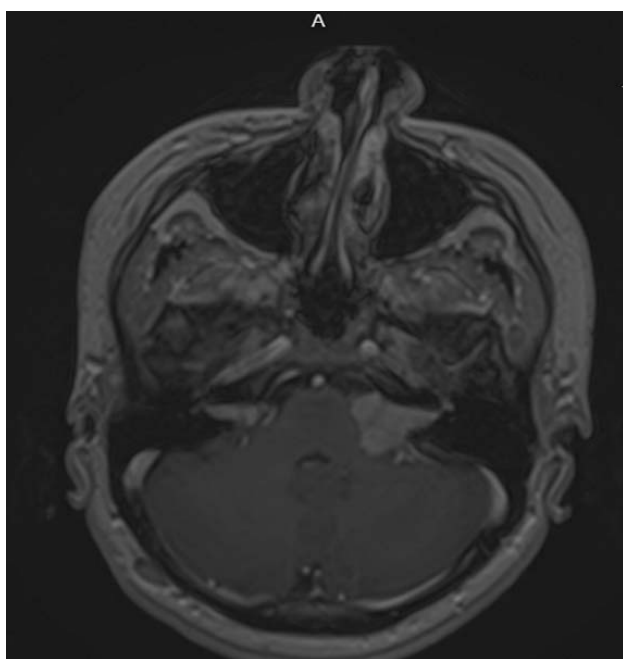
Pre Cyber Knife and Post Cyber Knife treatment MRI images respectively in a patient with bilateral VS
